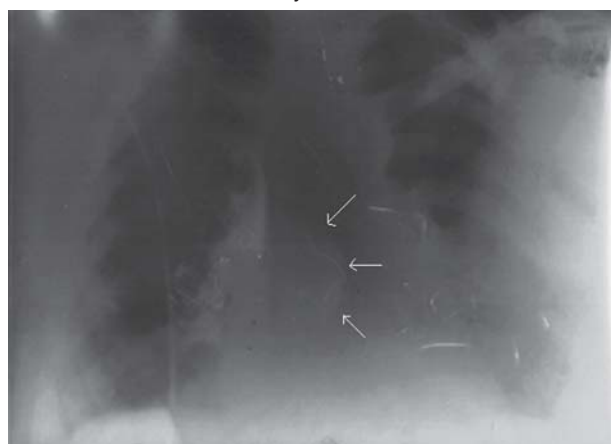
Chest radiograph (postero-anterior view) showing an oval radio-opaque mass within the cardiac shadow (arrows).
